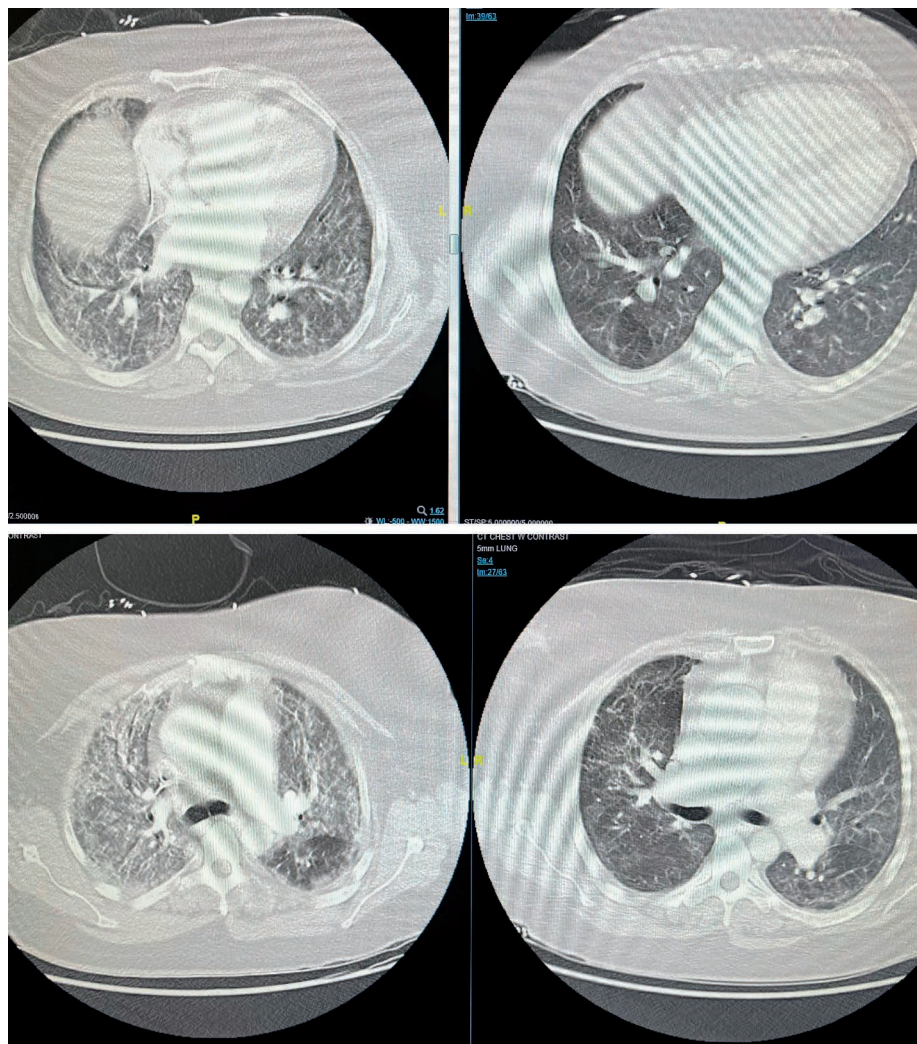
Computed tomography chest comparison, April 2020 to June 2020 (lower lobes).
